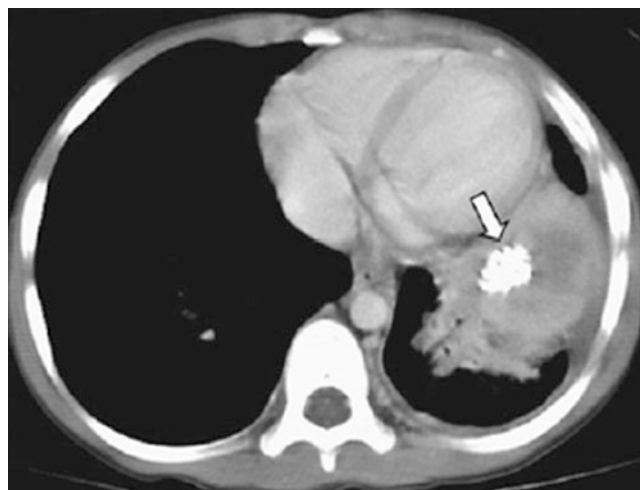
A 6-year-old girl who presented with fever and abnormal chest radiographs. Enhanced axial CT image demonstrates a heterogeneously enhancing mass with associated chunky calcification (arrow) in the left lower lobe. Surgical pathology confirmed a diagnosis of inflammatory pseudotumor
